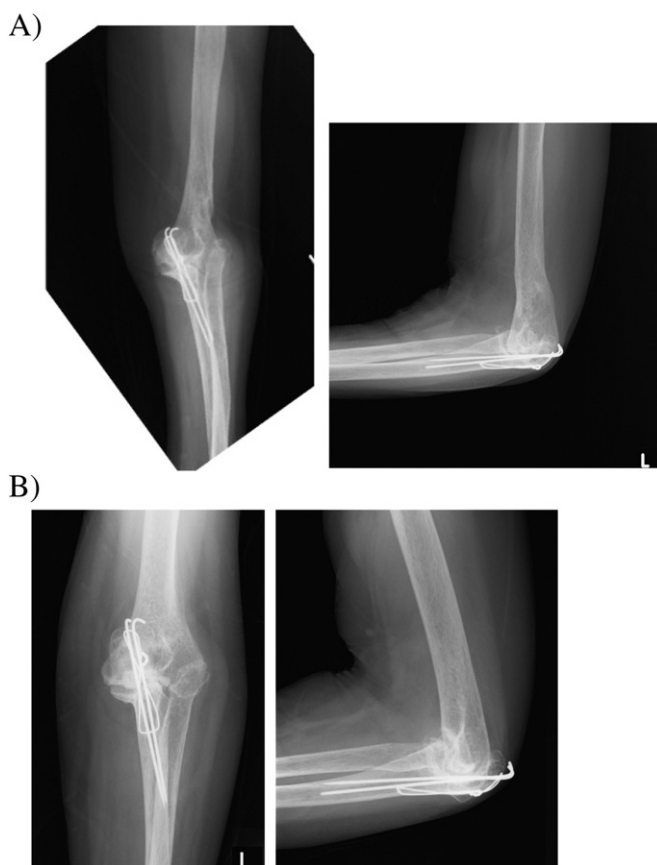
Comparison of X-rays obtained at the final follow-up examination and before the injury. The alignment of the left elbow at 18 postoperative months (A) was comparable with that seen before the present injury (B).
